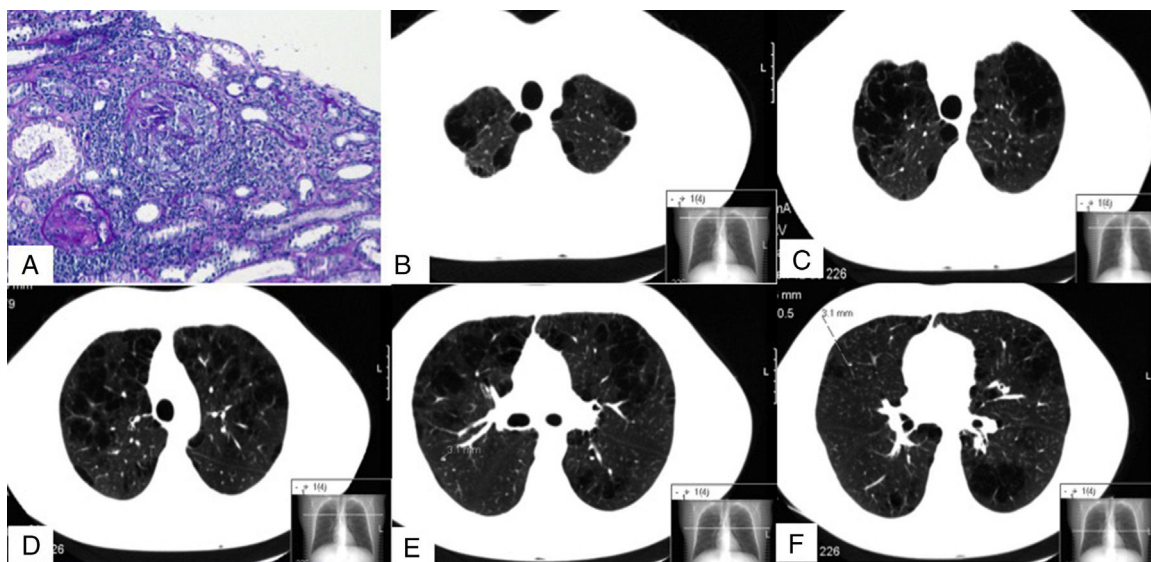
Images of renal biopsy (A) and chest CT (B–F). (A) 2 glomeruli with extracapillary (or crescent) proliferation (periodic acid Schiff). (B–F) Different chest CT slices showing bilateral mixed centrilobular emphysema, with areas of paraseptal involvement and subpleural bullae, mainly in the upper lobes. (F) One of the nodules, measuring 3.1 mm (dotted line).
